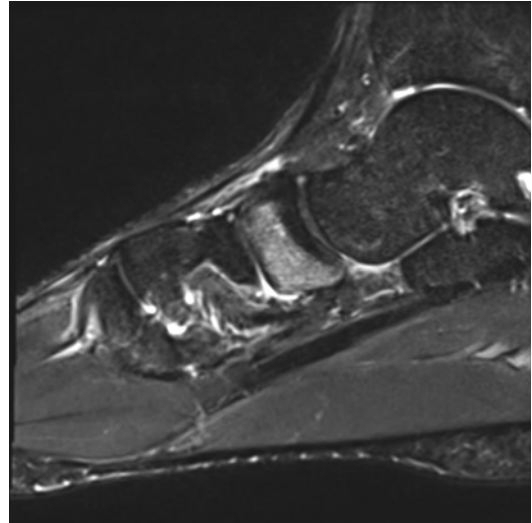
T2 axial cut MRI demonstrating a Grade I stress fracture of the navicular in a 22-year-old male collegiate distance runner. The patient presented with pain over the third metatarsal shaft with no pain or tenderness at the navicular. A Grade II stress fracture was evident at the third metatarsal
